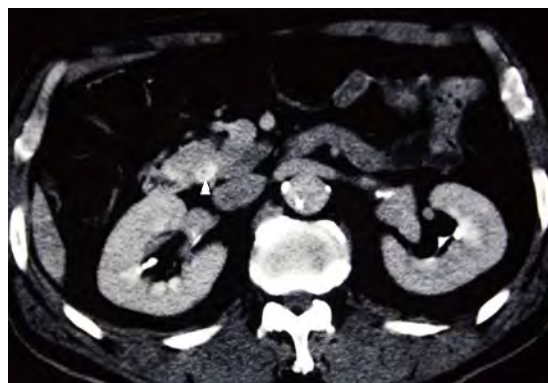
Abdominal computed tomography angiography image of the common bile duct. Thickening of the wall of the distal common bile duct, which enhances with contrast, was observed (arrowhead).
